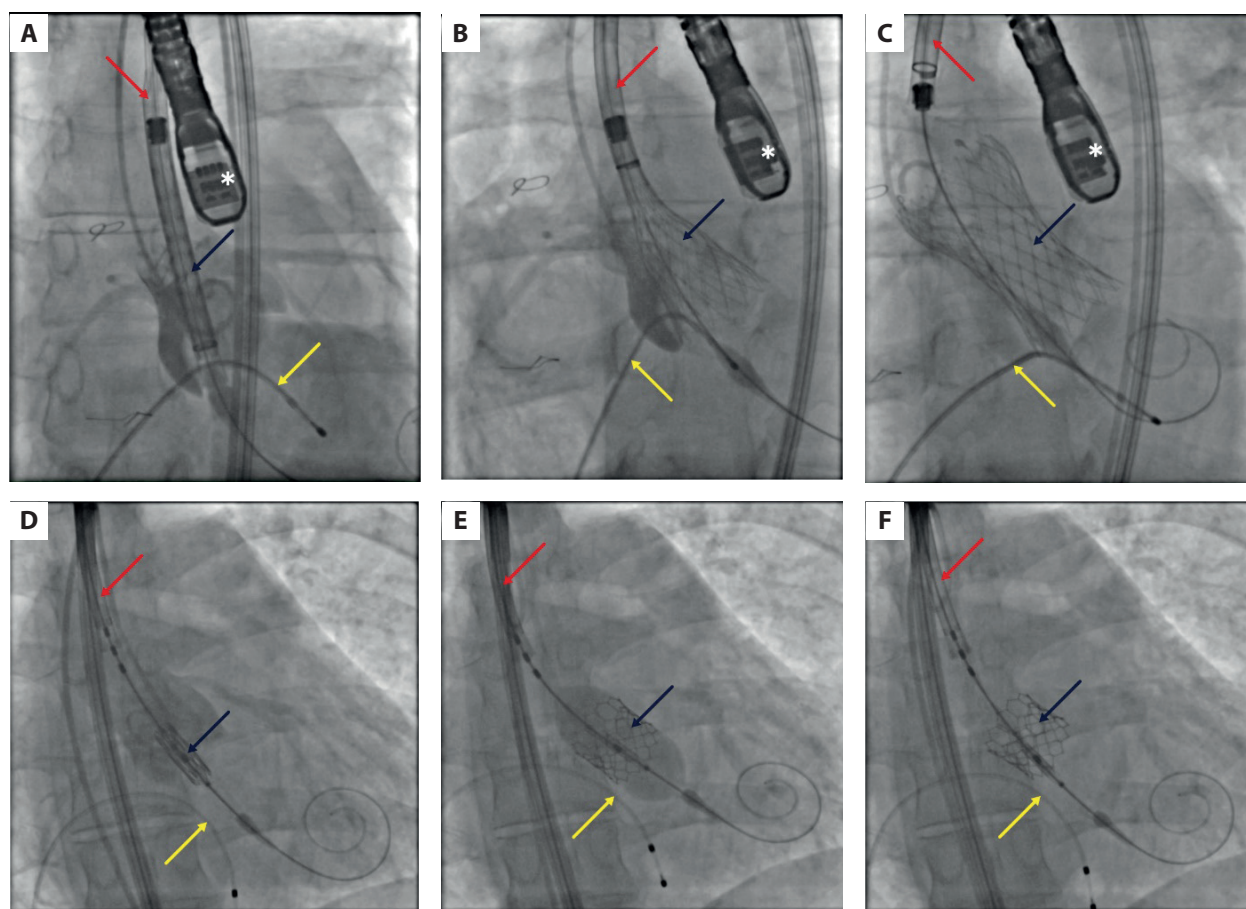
A–C. Course of the transcatheter aortic valve implantation procedure in the first patient: valve positioning (A), gradual valve self-expansion by pulling the delivery catheter upwards (B), and control fluoroscopy (C). The Evolut R34 valve (dark blue arrow), delivery catheter (red arrow), temporary pacemaker lead in the right ventricle (yellow arrow), and transesophageal echocardiography probe (white asterisk) are visible. D–F. Course of the transcatheter aortic valve implantation procedure in the second patient: valve positioning (D), balloon expansion of the valve (E), and control fluoroscopy (F). The SAPIEN 3 valve (dark blue arrow), delivery catheter (red arrow), and temporary pacemaker lead in the right ventricle (yellow arrow) are visible
